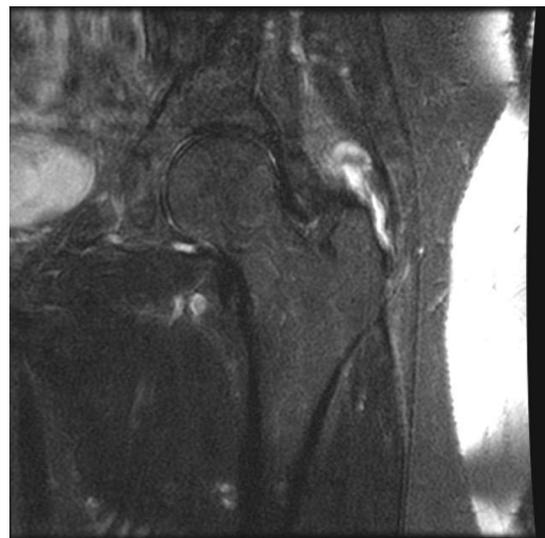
MRI of the left hip demonstrates tendon discontinuity, partial tearing, or fatty infiltration of the gluteus medius and minimus.
